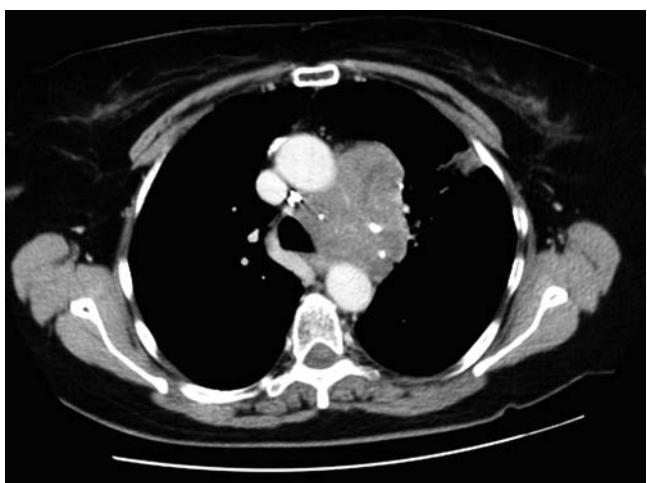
CT of chest from a patient with biopsy proven small cell carcinoma. Note large mediastinal mass next to the aorto-pulmonary window.
